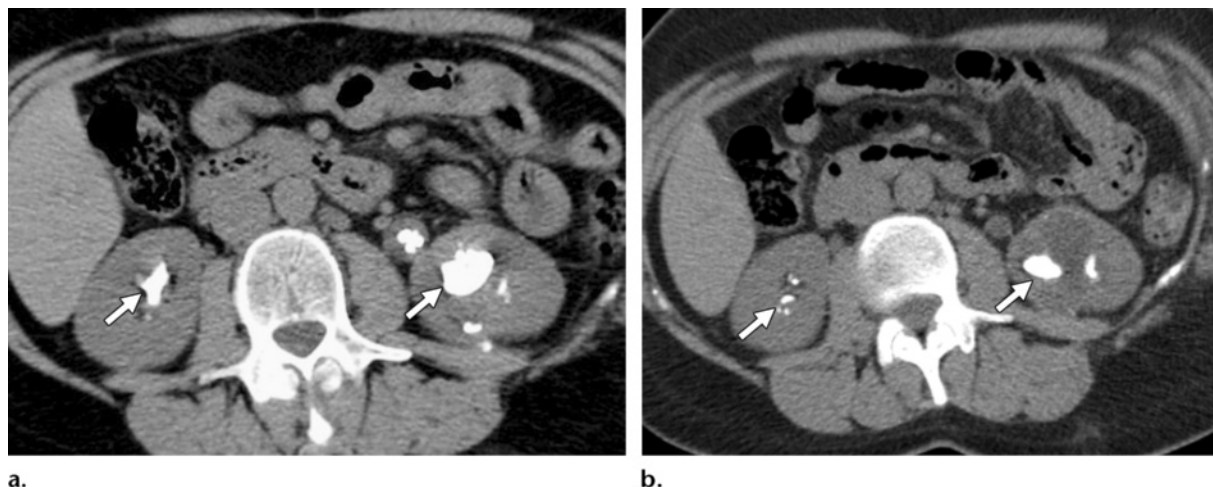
Bilateral staghorn calculi in a 52-year-old man. (a) CT scan obtained prior to SWL shows bilateral staghorn calculi (arrows) with left proximal ureteral calculi. (b) Posttreatment CT scan shows several residual fragments in both renal pelves (arrows). The patient underwent PCNL for removal of the residual fragments.
